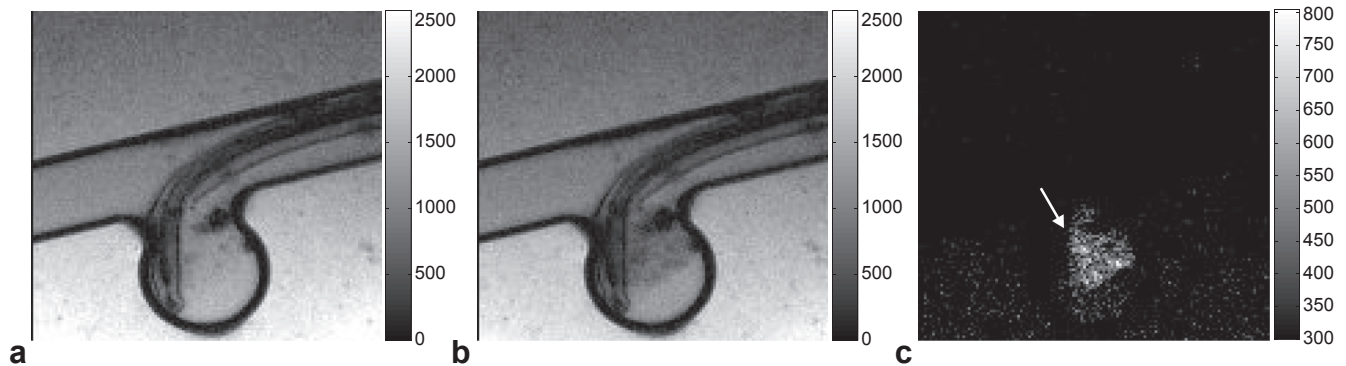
MT images acquired before (a) and after (b) coagulation. The hyperintense regions in the image showing the difference (arrow, c) indicate the location and morphology of the coagulum. MT MR imaging enables intraprocedural monitoring of the progress of coagulation.
